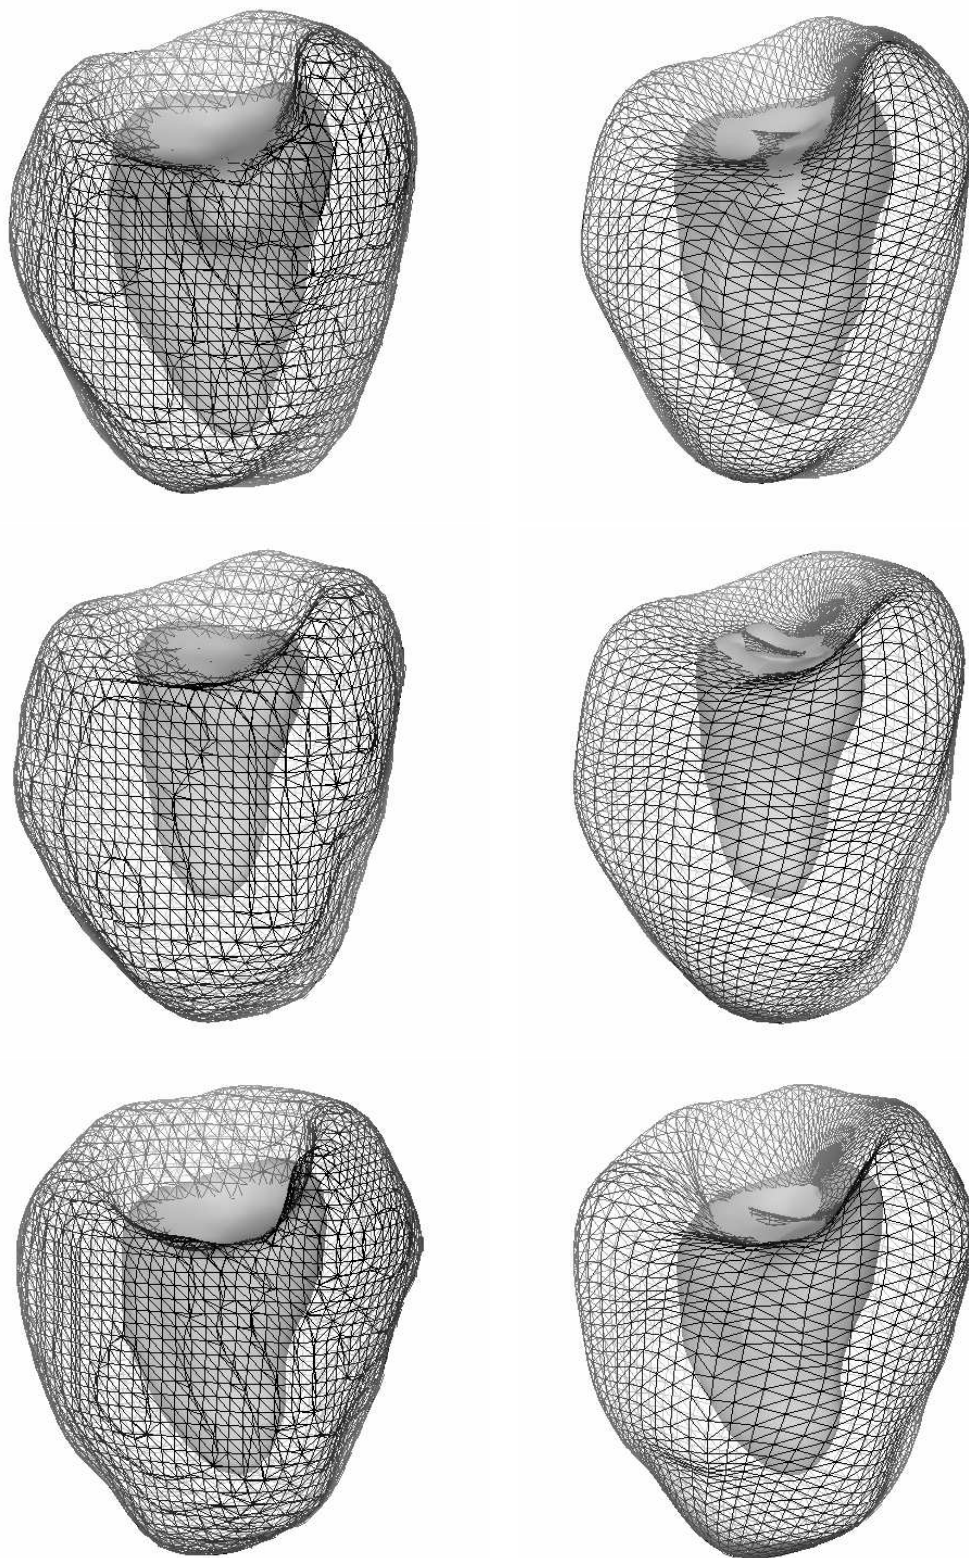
Time sequence of the epicardium (mesh) and the endocardium (rendered surface) - SPECT image. On the left : isosurfaces obtained by data segmentation (4500 + 1500 points). On the right : representation by two parametric models ( $2 \times 130$  parameters).
